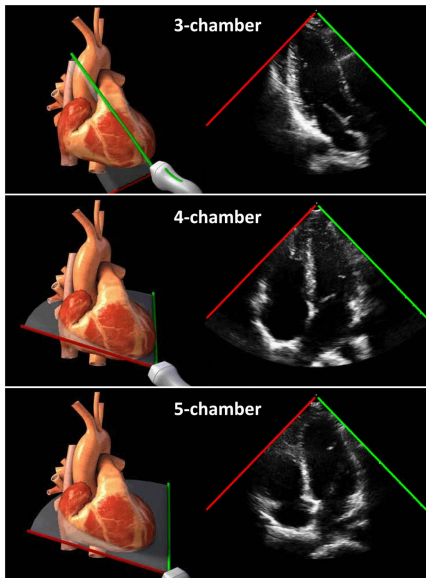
Three standard echocardiographic apical views. In the present study, the 3-, 4P- and 5-chamber views were all analyzed by high-frame Doppler vortography. Images reproduced with permission from <http://pie.med.utoronto.ca/tte>.
